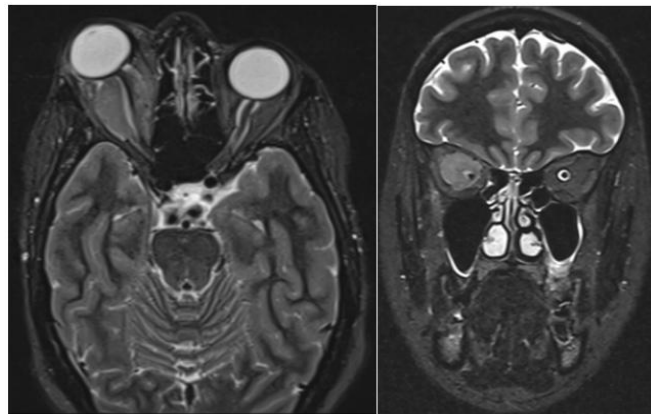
Axial (a) and coronal (b) MR image (T2 with fat saturation). The lesion is slightly hyperintense to the optic nerve (arrow)
